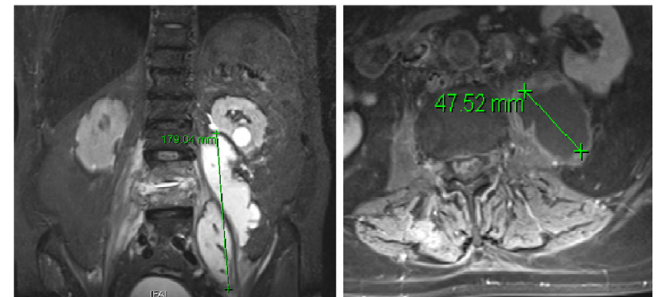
MRI: L3-L4 spondylitis with edema of the vertebral bodies and disc, enhanced after injection. Very large left psoas abscess interesting lumbar and iliopsoas, measuring 18x 5 cm. There are also epidural abscess facing the vertebral involvement and a prevertebral spindle.
